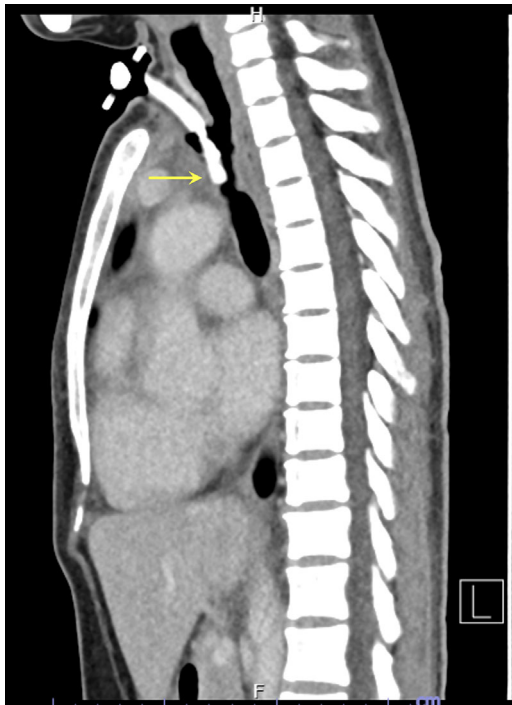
CT of the chest and neck (sagittal view) showing the narrowest luminal portion of the distal trachea that is located at the T4–T6 level (arrow)
